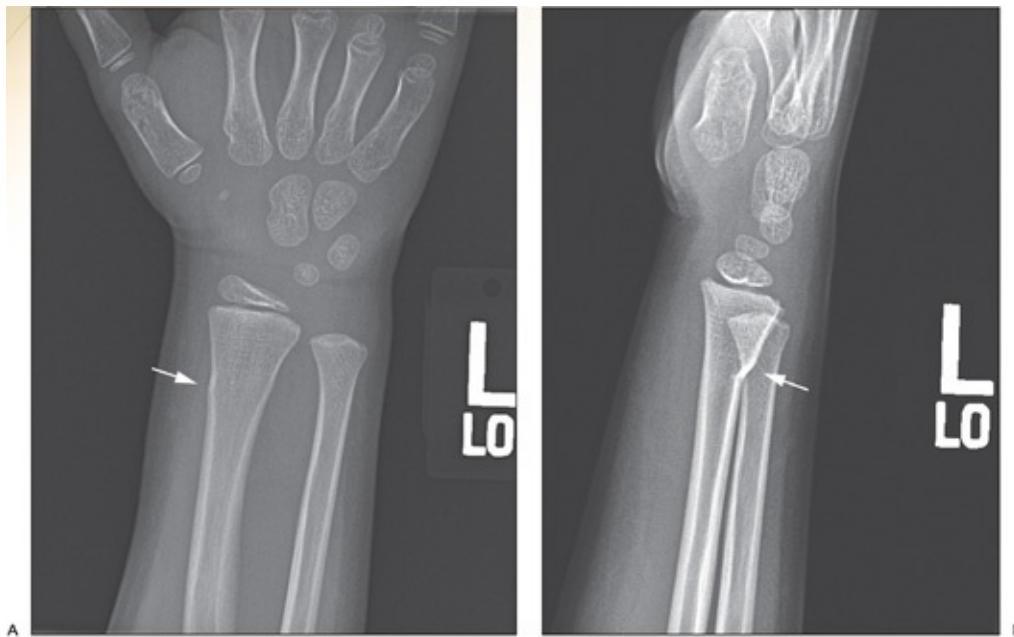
A: AP. B: Lateral radiographs of a torus fracture of the distal radius (arrows).
